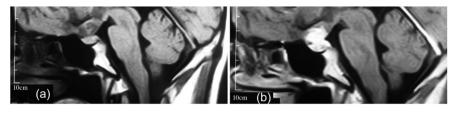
(a, b) MRI revealing a well-delineated round tumor 30 × 25 × 20 mm in diameter, T1W isointense and T2W hyperintense lesion located within the sella turcica and another dural-based lesion lying over the diaphragm sella extending to the planum sphenoidale. The intrasellar lesion showing a faint enhancement after contrast material injection but the suprasellar lesion has a bright enhancement.
